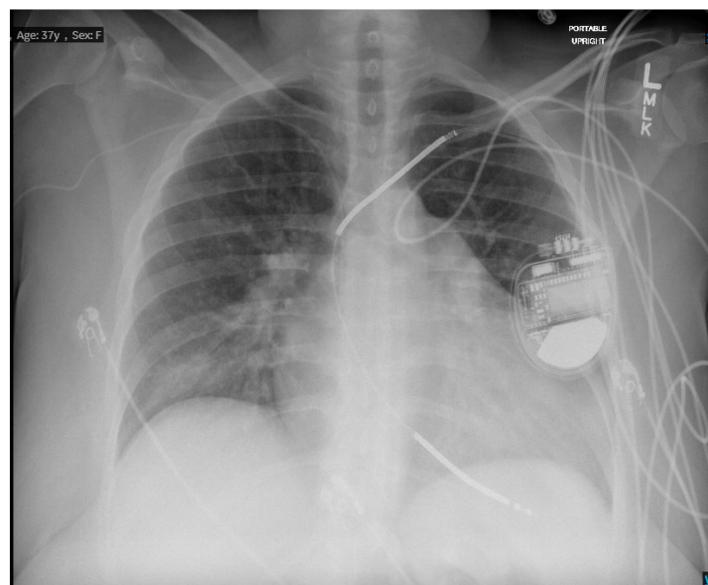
Chest x-ray on admission showing cardiomegaly and opacity in right lower lung.
